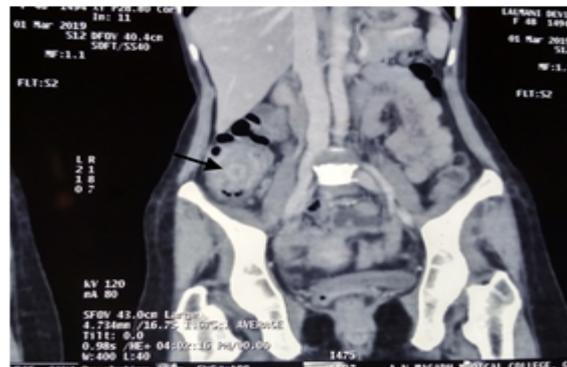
CT Abdomen showing Characteristic 'target sign' (Black Arrow)
